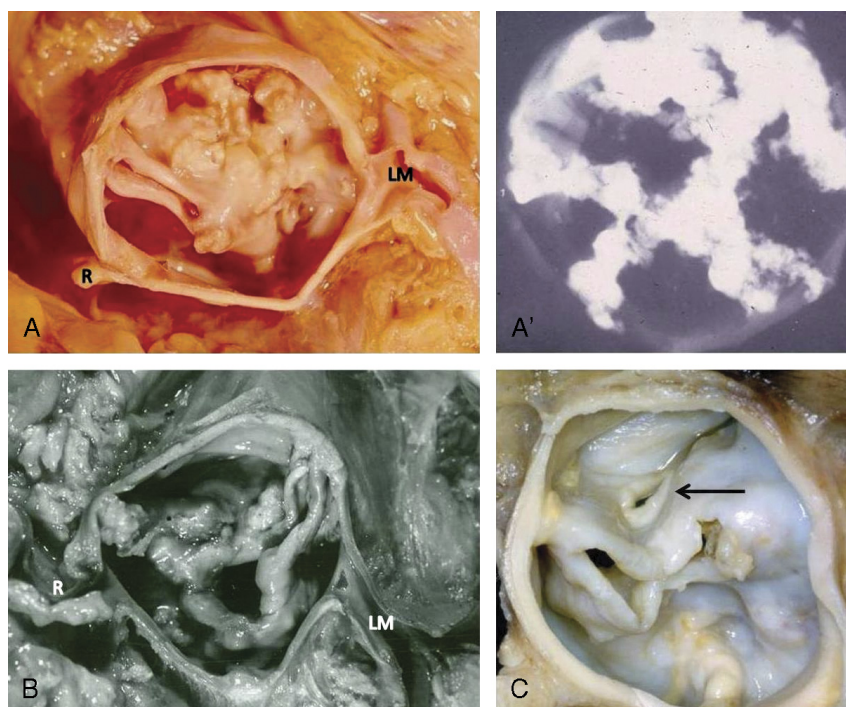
Unicuspid aortic valves in 3 patients. A and A' (radiograph), Valve of a 48-year-old man who had been well until 5 months before death when signs and symptoms of heart failure began and progressed. Terminally, he developed pneumonia, which prevented cardiac catheterization and cardiac valve replacement. The heart weighed 750 g. LM = left main coronary artery; R = right coronary artery. B, Valve of a 31-year-old man who had been a splendid 3-letter athlete and had won his country club golf championship several days before dying quickly of severe acute heart failure. The heart failure was the first he had ever had. The peak systolic pressure difference between left ventricle and aorta was 11 mm Hg. The patient also had considerable AR with similar diastolic pressures in both left ventricle and aorta (50 and 60 mm Hg respectively). He was deemed too sick to undergo aortic valve replacement in 1969. His heart weighed 880 g. C, Valve of a 26-year-old man who died suddenly while dancing in a disco. According to some friends, he had no known medical ailments and was not taking any medications. Prior to the sudden collapse there were apparently no complaints of feeling ill. The heart weighed 760 g. A cuspal perforation (arrow) is present, suggesting previous IE that had healed.
